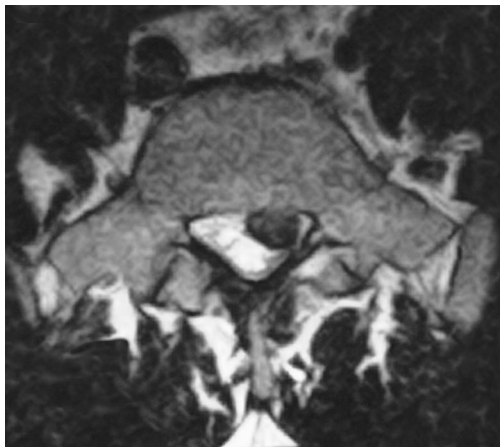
Axial T2-weighted magnetic resonance imaging scan of a large contained disc herniation that was treated surgically.
